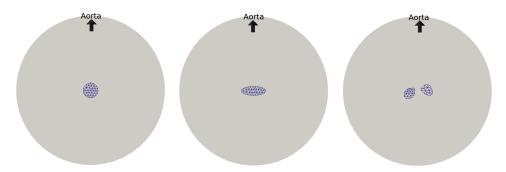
Hole configuration used in the presented work. The rightmost configuration is a mitral defect segmented from ultrasound images.
